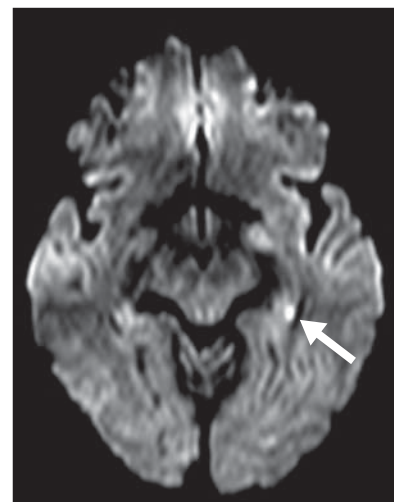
Diffusion-weighted magnetic resonance image, obtained 48 hours after onset, revealing a small diffusion restriction in the posterior left hippocampus (arrow).
